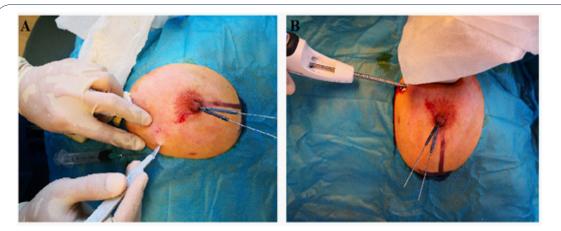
(A) Incision of 5 mm with the aid of scalpel for further Mammotome needle puncture; (B) 8 Gauge needle of the rotary cutter was punctured into the skin with an incision of a length about 5 mm. The sonographic probe was wrapped up in sterile medical gloves covered by gauze. Simultaneously enable, the rotary cutter was vertical to the long axis of the probe of sonography to be accessible to visualization of breast mass where the rotational cutter was inserted under mass subcutaneously for lesion removal via rotation of both of which till without residuals.
